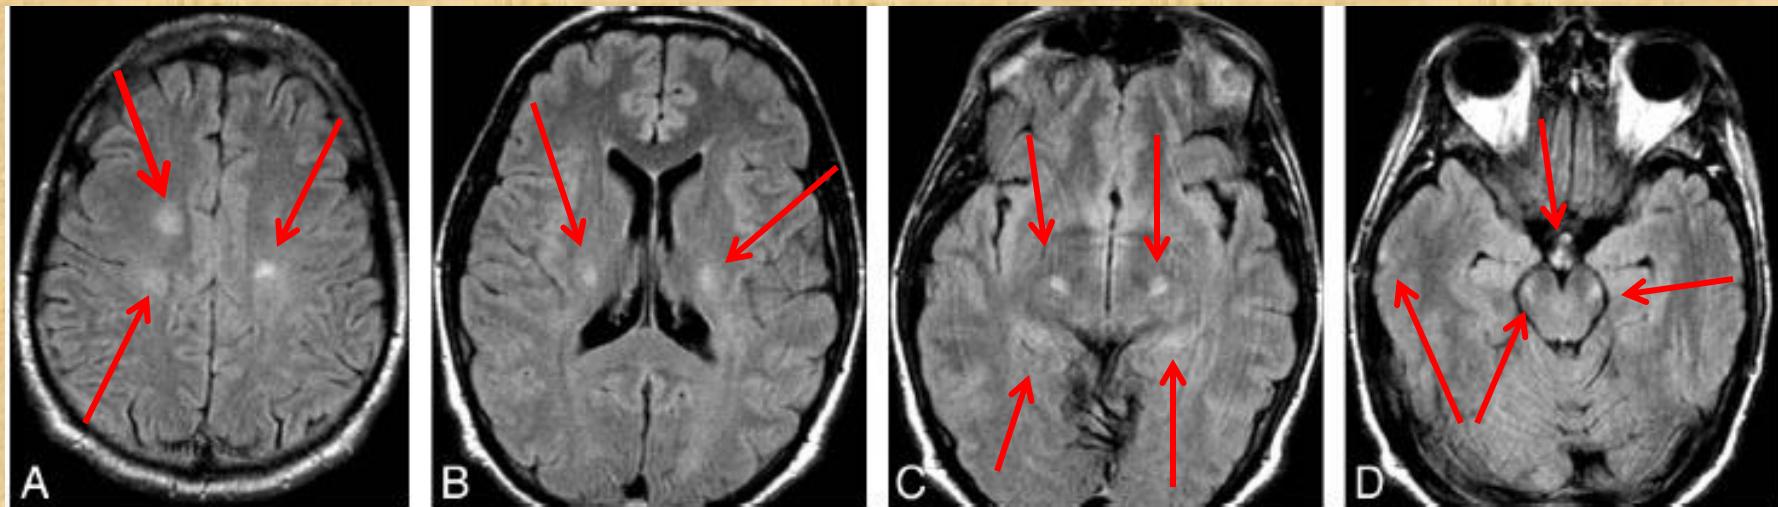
FLAIR images from initial brain MR imaging demonstrate abnormal increased signal intensity in the white matter of the centra semiovale and bilateral corticospinal tracts.
